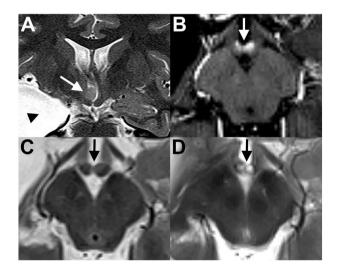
Coronal T2-weighted MRI demonstrating prior right temporal lobectomy (black arrowhead) and ectopic gray matter along the right lateral wall of the hypothalamus (white arrow) (A). There is also subtle right mammillary body atrophy at this time. Panels B and C show cropped axial postcontrast T1 and axial T2 of the midbrain and mammillary bodies 3 weeks after successful MRI-guided laser ablation of the hypothalamic hamartoma. There is new enhancement (white arrow, panel B) and subtle T2 hyperintensity in the medial aspects of both mammillary bodies (black arrow, panel C) concerning perioperative tissue injury. Follow-up axial T2 MRI 6 months later shows abnormal T2 hyperintensity and atrophy of both mammillary bodies (black arrow, panel D), confirming that significant tissue injury occurred.
